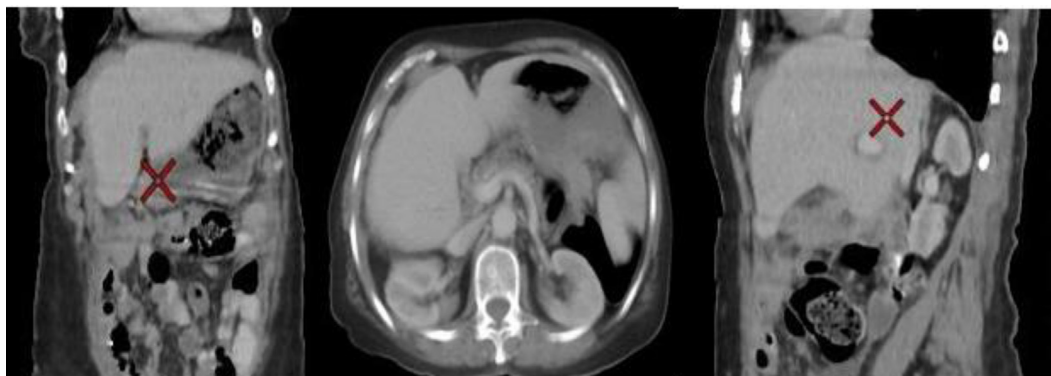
A 50-year-old woman with cancer ovary and suspected with peritoneal carcinomatosis. Coronal, axial, and sagittal reformatted portal venous phase. CT images showed multifocal discrete nodules in the peritoneal cavity mainly at the surface of the diaphragm, peritoneal enhancement, and thickening and omental haziness.
